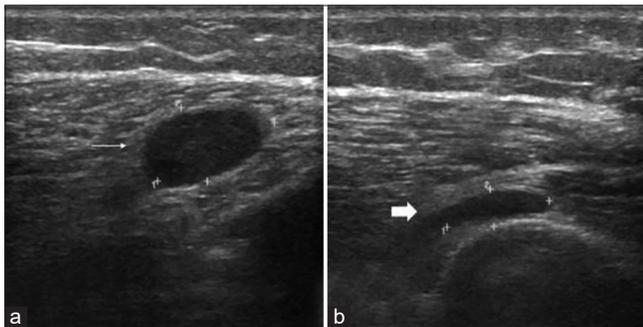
Gray scale ultrasound image showing well-defined oval hypoechoic lesions in vastus medialis (thin arrow in a) and based on periosteum of diaphysis of the left femur (thick arrow in b).
